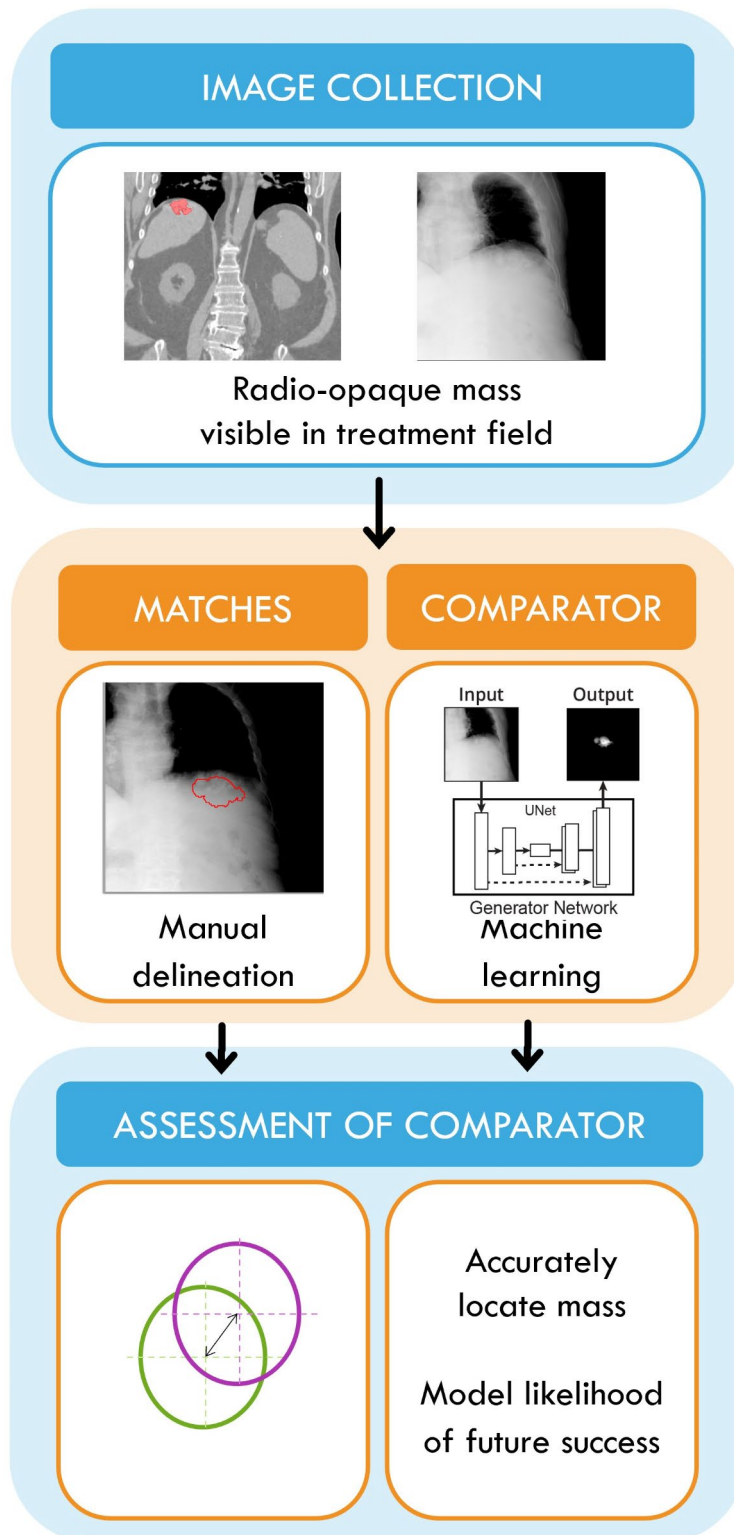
Study Design. Standardly collected radiation therapy planning, CBCT projections and intra-treatment monitoring images will be used to create manually delineated matches. After improvement of existing mass-detecting software (KIM) through machine learning, the updated algorithm will be applied to un-delineated images to (i) detect the contrast mass, and (ii) locate its centre in comparison with manually delineated matches. If the contrast mass can be detected accurately, modelling for likelihood of KIM tracking success will be conducted
